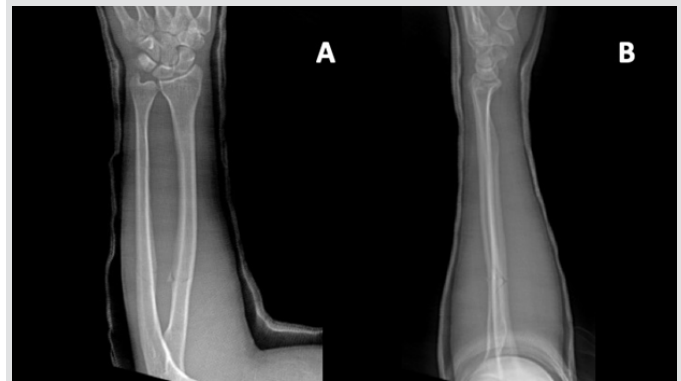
AP (a) and lateral (b) X-rays demonstrate the both bone forearm fractures with interval cast placement without any new fracture displacement or angulation.
